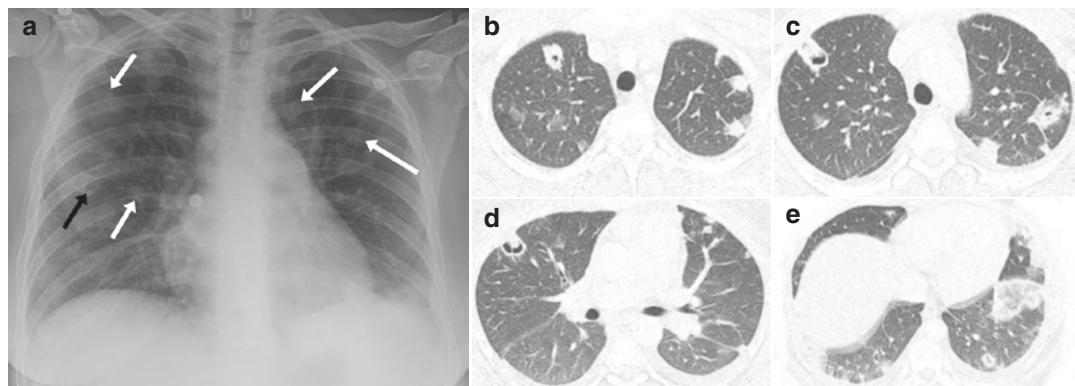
Septic emboli in a 28-year-old woman with a history of intravenous drug use. AP chest radiograph (a) demonstrates multiple nodules (white arrows) and area of ill-defined air-space consolidation in the left lower lobe. A
